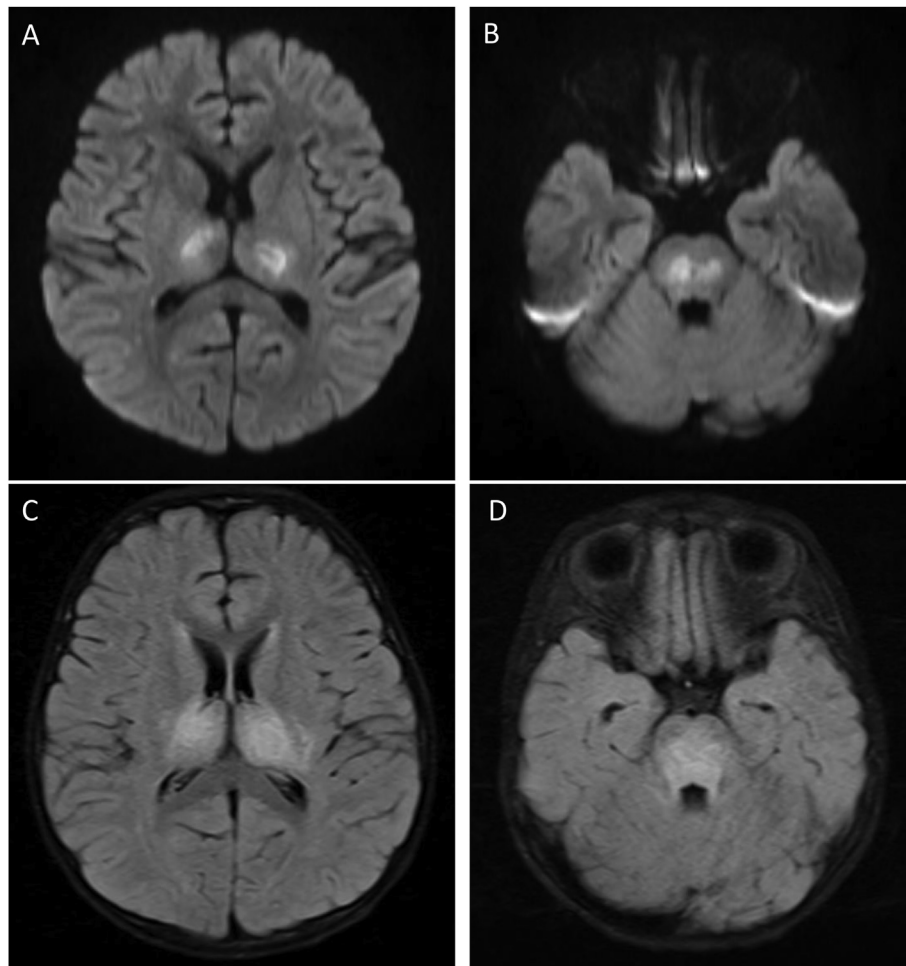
Brain magnetic resonance imaging. Diffusion-weighted images reveal peripheral diffusion restriction in bilateral thalami (A) and pons (B). T2-weighted-fluid-attenuated inversion recovery images of the same cuts as diffusion-weighted images shows edema in bilateral thalami (C) and pons (D).
